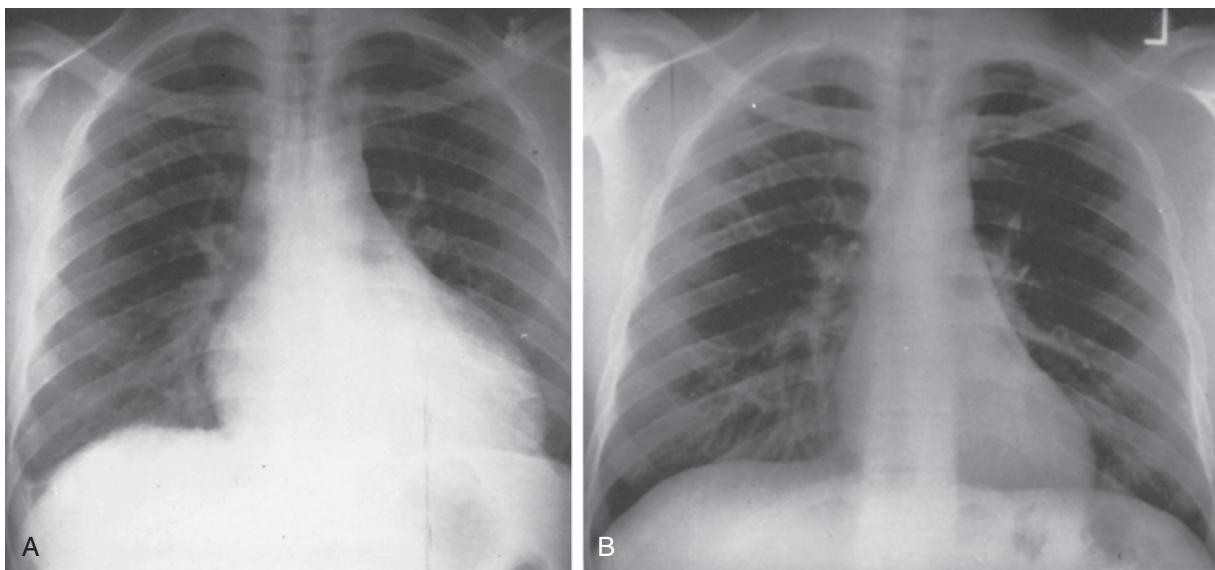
From Jay M. Plain Film in Heart Disease. Boston: Blackwell Scientific Publishing; 1992.
